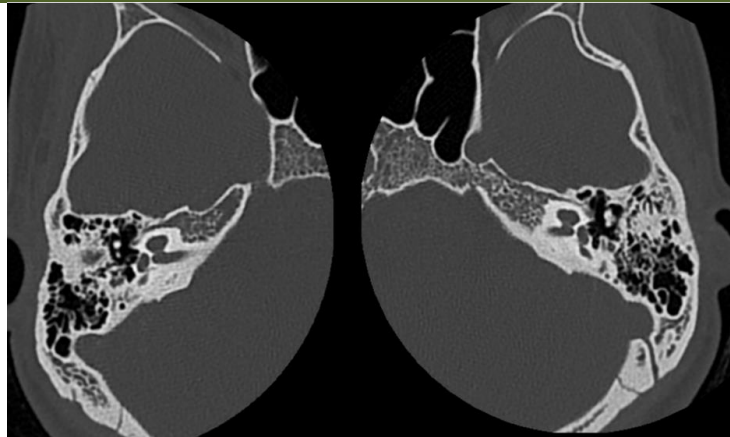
Axial HRCT image demonstrating incomplete partition type II (Mondini malformation) characterized by a preserved basal turn, cystic dilatation of the apical cochlea, reduction of the cochlea to 1.5 turns, absence of the modiolus, and associated enlarged vestibular aqueduct.
